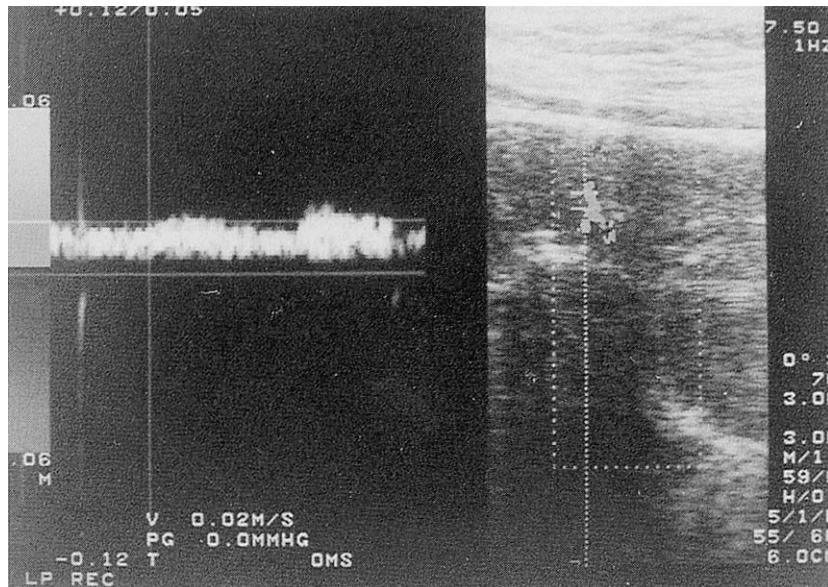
Color Doppler flow image of the anterior bladder wall in a 68 year-old male patient with infravesical obstruction due to benign prostatic hyperplasia. The ultrasound estimated bladder weight was 95.7 g. The sound spectrogram showed a non-pulsatile blood flow.
